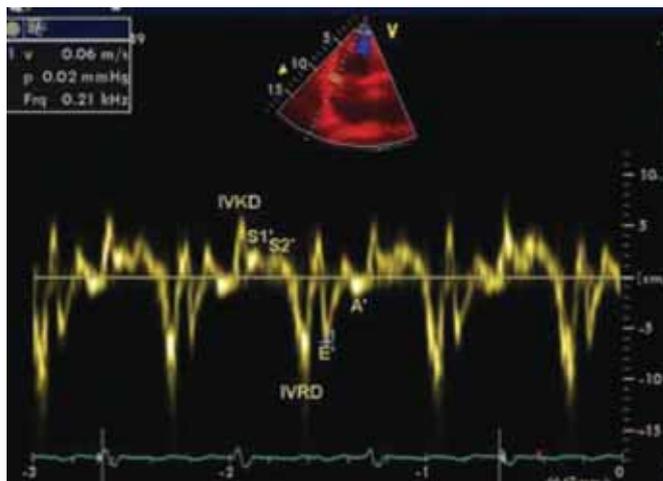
In the tissue Doppler analysis of the lateral mitral annulus, E' velocity was found below 8 cm/sec suggesting the diagnosis of restrictive cardiomyopathy. IVKD: isovolumetric contraction wave; IVRD: isovolumetric relaxation wave.
